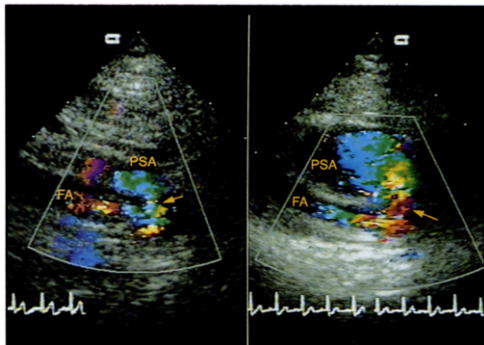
Patient 1. Doppler color flow ultrasonogram in the noninvasive closure of a femoral artery pseudoaneurysm after coronary angioplasty. The femoral artery (FA) and pseudoaneurysm (PSA) are shown in the long-axis view. Left, A small residual pseudoaneurysm cavity (PSA) and the tract (arrow) after the first external compression are shown. Right, Repeat post-compression imaging of the femoral artery 24 h after ambulation demonstrating a marked increase in the size of the pseudoaneurysm.
